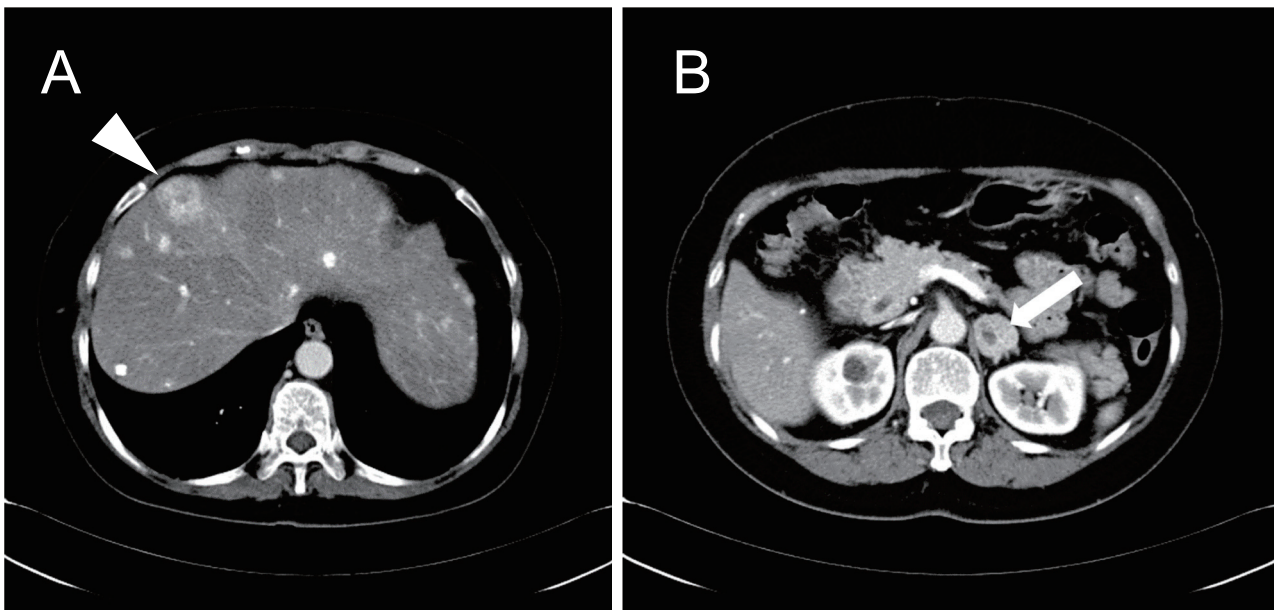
Contrast computed tomography of the abdomen. The white arrowhead indicates liver metastasis of medullary thyroid carcinoma (A). The white arrow indicates a left adrenal tumor (B).
